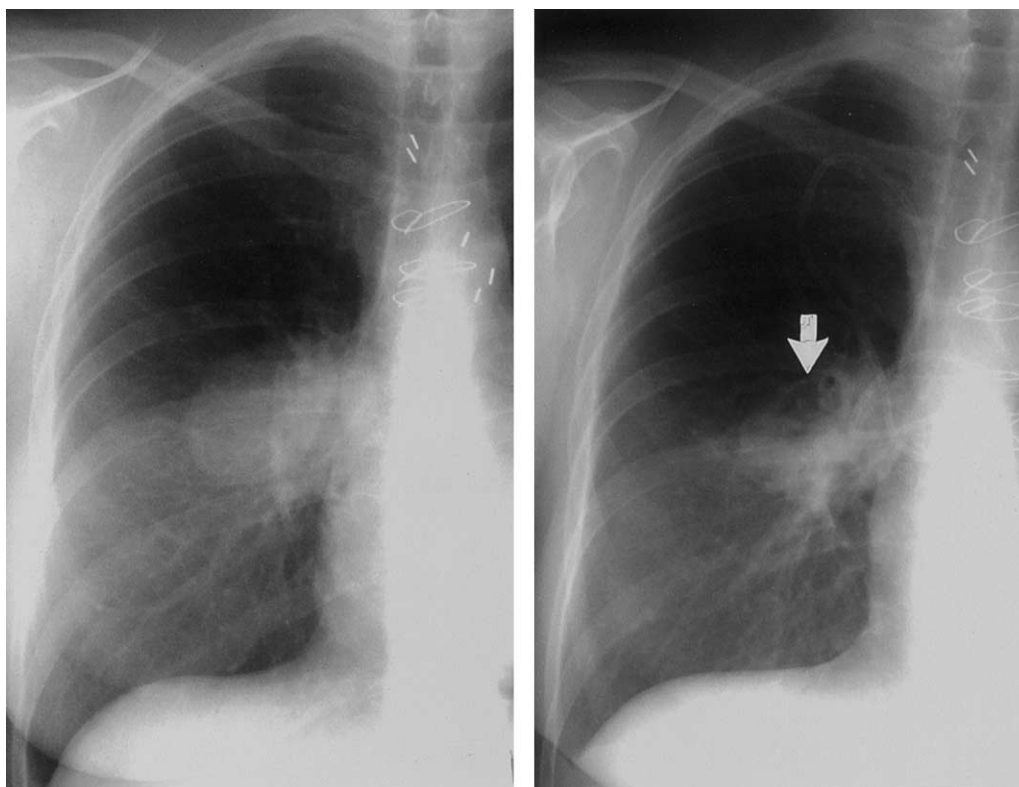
Development of cavitation in a 50-year-old heart transplant recipient. A, Radiograph obtained at the time of initial detection, showing a 5-cm mass in the right lower lobe; B, Radiograph obtained 11 days later, showing interval development of cavitation (arrow).
